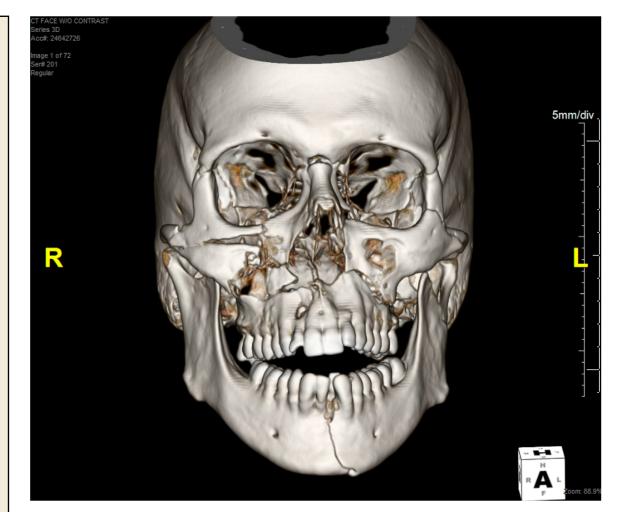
CT face 3D reconstruction demonstrating complex maxillofacial fractures
